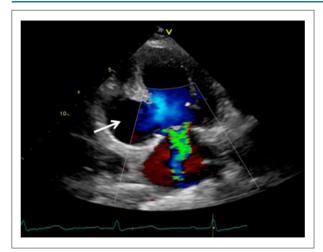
Transthoracic echocardiography (apical 2-chamber view) showing aneurysmal formation (arrow).
